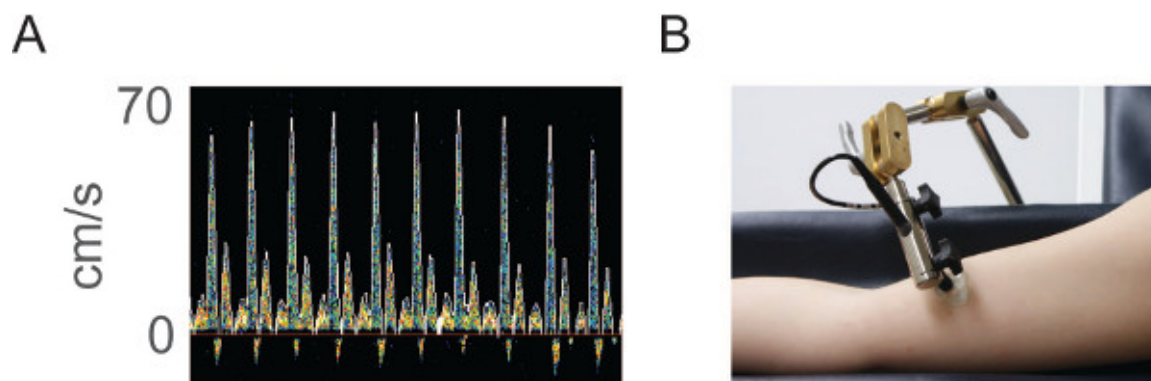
Brachial blood flow velocity measurement. A. The brachial ultrasound probe is positioned overlying the brachial artery to enable measurements of forearm blood flow velocity, and the calculation of vascular resistance responses. B. Once in place, the probe is secured using an adjustable clamp to ensure the angle of insonation does not change throughout the test.
